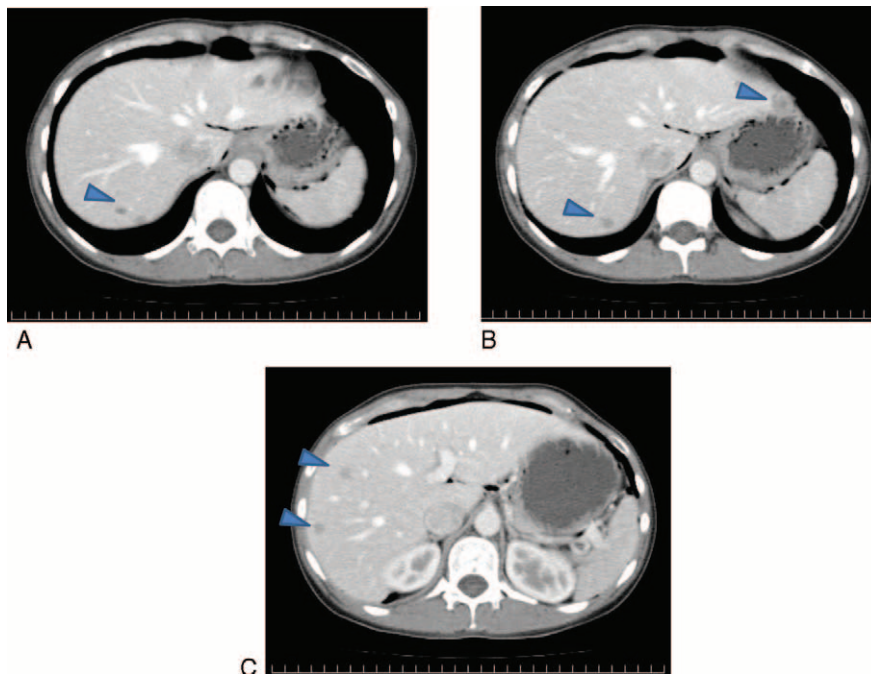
Contrast-enhanced computed tomography images from before the start of bevacizumab/paclitaxel/carboplatin therapy in 2009. Low-density masses are visible in both liver lobes: (A) low-density masses in S7, (B) low-density masses in S2 and S7, and (C) low-density masses in S8 (arrows indicate lesions).
